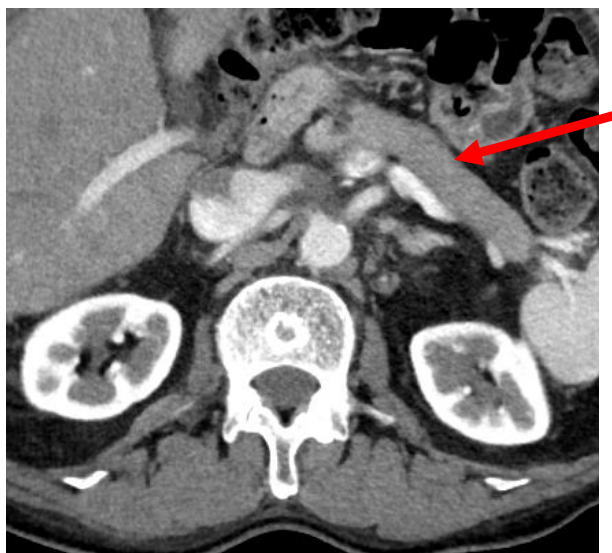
Axial view of pancreatic dynamic contrast-enhanced CT. The arrow indicates diffuse enlargement of the pancreas.
